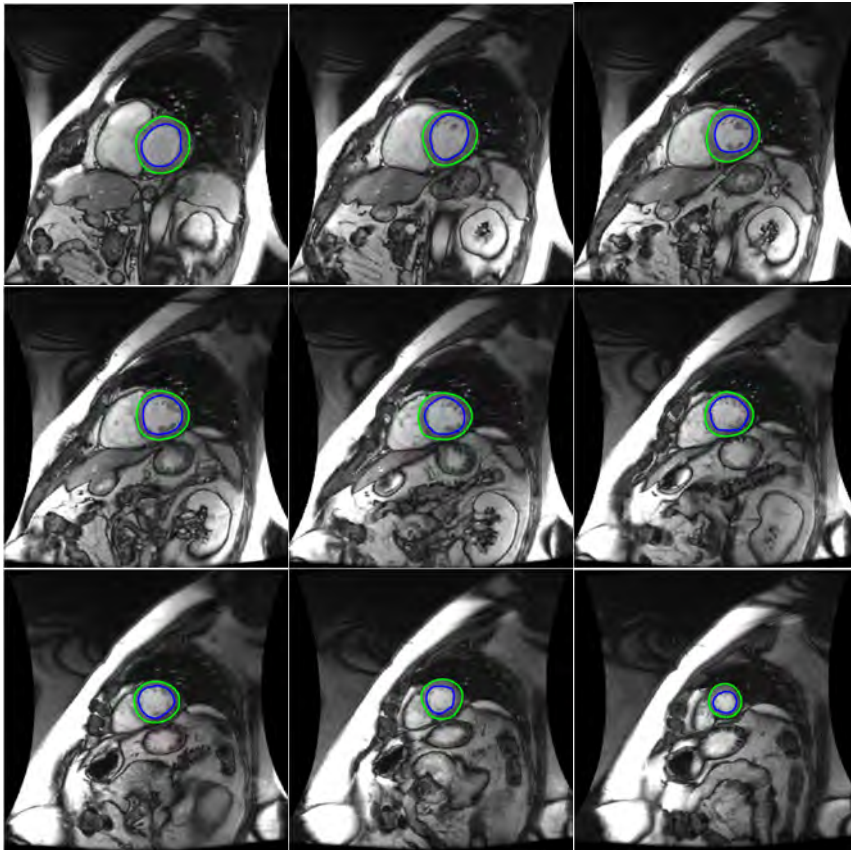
SAV MRI from SCD at the end diastolic cardiac phase for a patient with no cardiac abnormalities with segmentation performed on left ventricle endocardium (blue contours) and epicardium (green contours) from the base slice (upper left image) to apex slice (lower right image)
